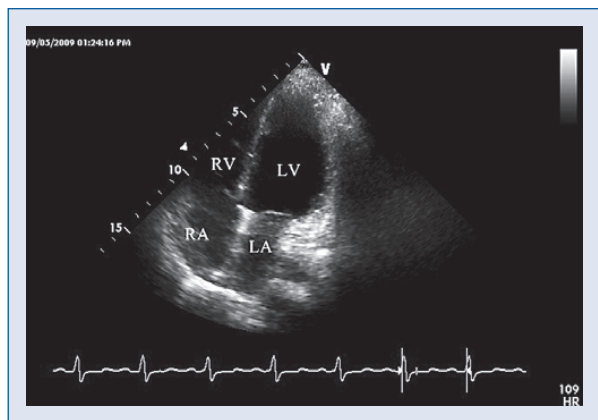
Post-operative transthoracic echocardiography, apical 4-chamber view showing the right atrial cavity free of thrombi; LA — left atrium; LV — left ventricle; RA — right atrium; RV — right ventricle.
